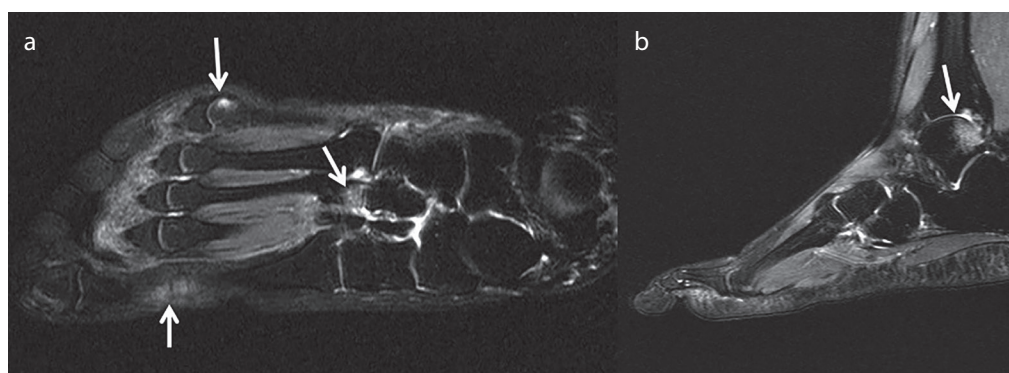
a, b. Magnetic resonance imaging (T2 W SPAIR) of the foot with axial (a) and sagittal views shows bone marrow edema and microcysts in the first and fifth metatarsophalangeal heads (b), third metatarsal base (a), and talar dome (b).
